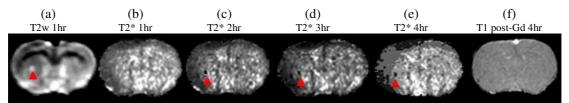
MRI images acquired following microinjection of MCP-1 into the left striatum. The arrow indicates the injection site.
